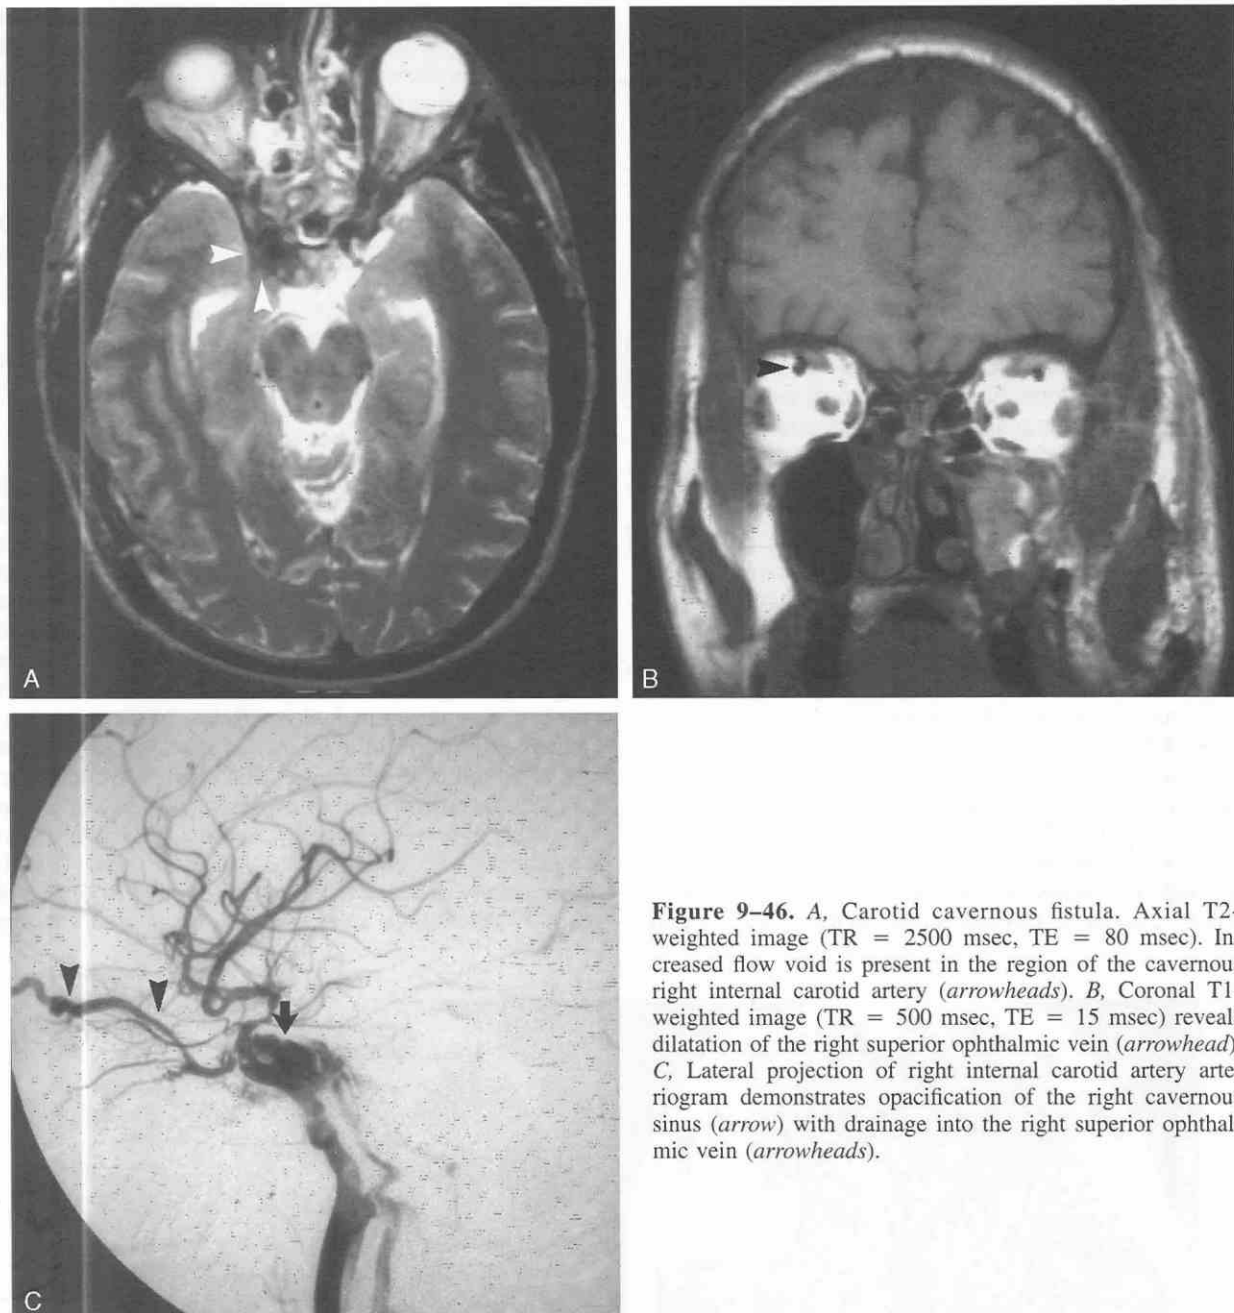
A, Carotid cavernous fistula. Axial T2-weighted image (TR = 2500 msec, TE = 80 msec). Increased flow void is present in the region of the cavernous right internal carotid artery (arrowheads). B, Coronal T1-weighted image (TR = 500 msec, TE = 15 msec) reveals dilatation of the right superior ophthalmic vein (arrowhead). C, Lateral projection of right internal carotid artery arteriogram demonstrates opacification of the right cavernous sinus (arrow) with drainage into the right superior ophthalmic vein (arrowheads).
